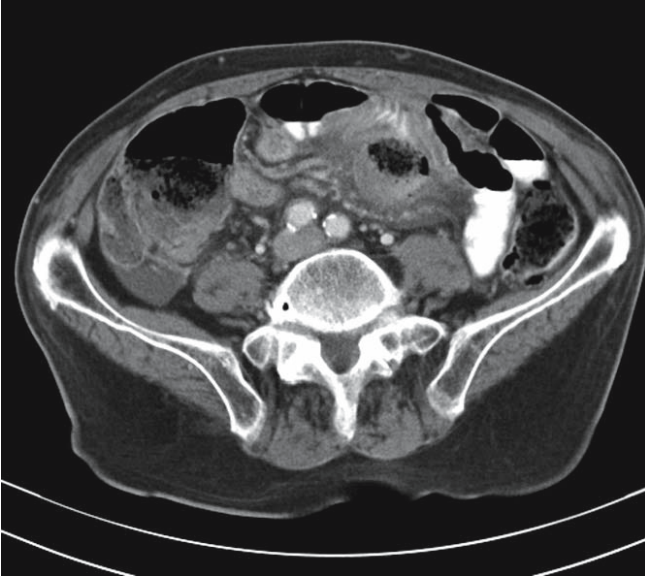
Abdominal CT: perforation of a Meckel's diverticulum. Note the central structure which lacks luminal contrast and is surrounded by tissue reaction
